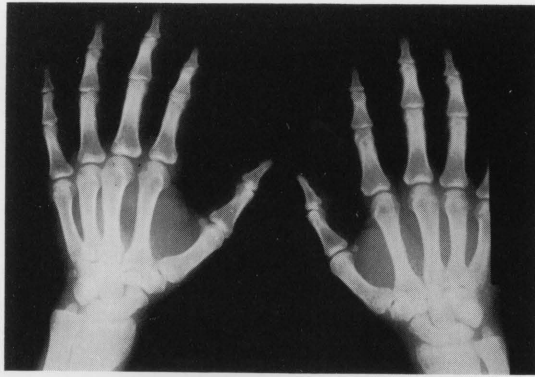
X-ray graphy of the patient was normal.
